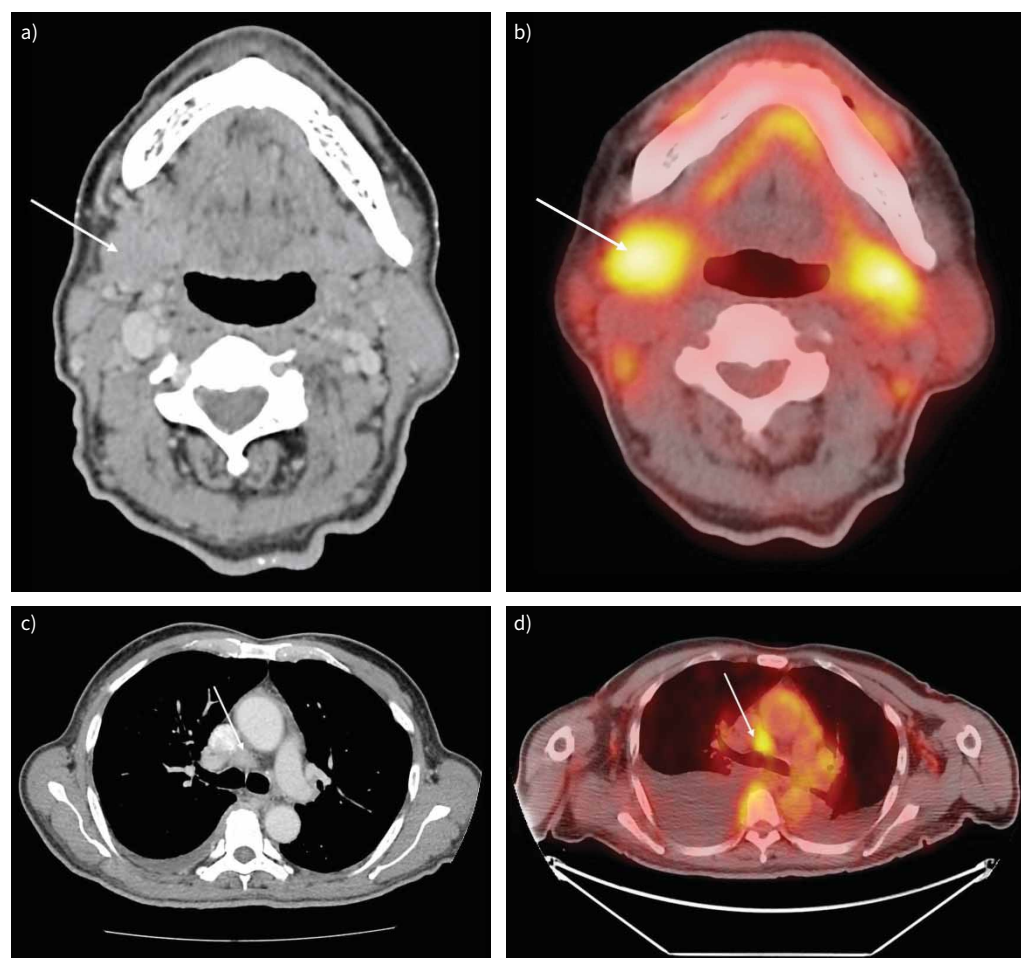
Computed tomography (CT) scan and ^{18}F -fluorodeoxyglucose positron emission tomography (^{18}F -FDG/PET) CT of a, b) the submandibular glands and c, d) at the level of pre-carina region.
